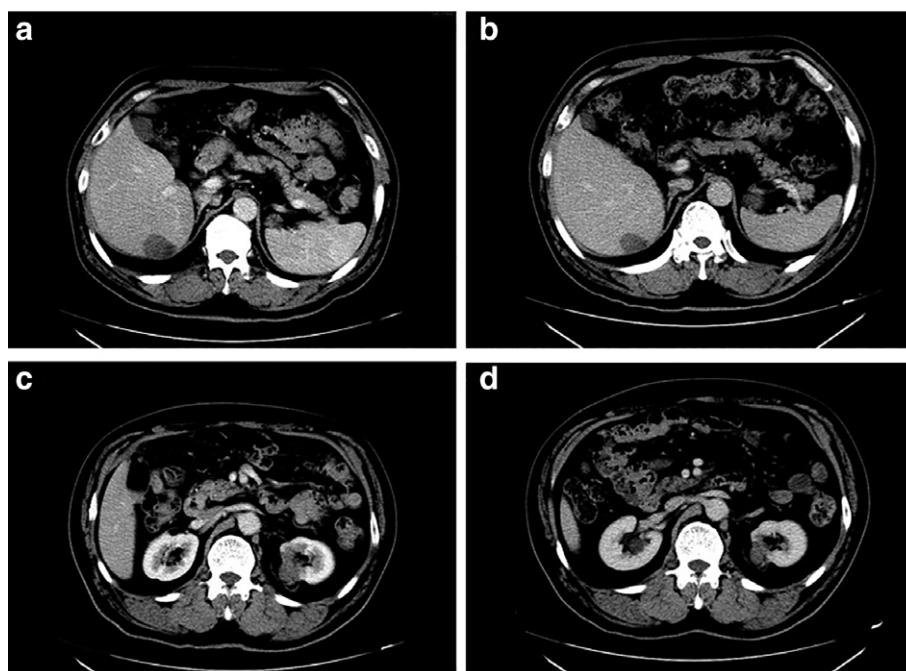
One month after ablation, contrast enhanced computed tomography showed no recurrence in either the (a) liver or (b) kidney. At the two year follow-up, computed tomography showed no recurrence in either the (c) liver or (d) kidney.
